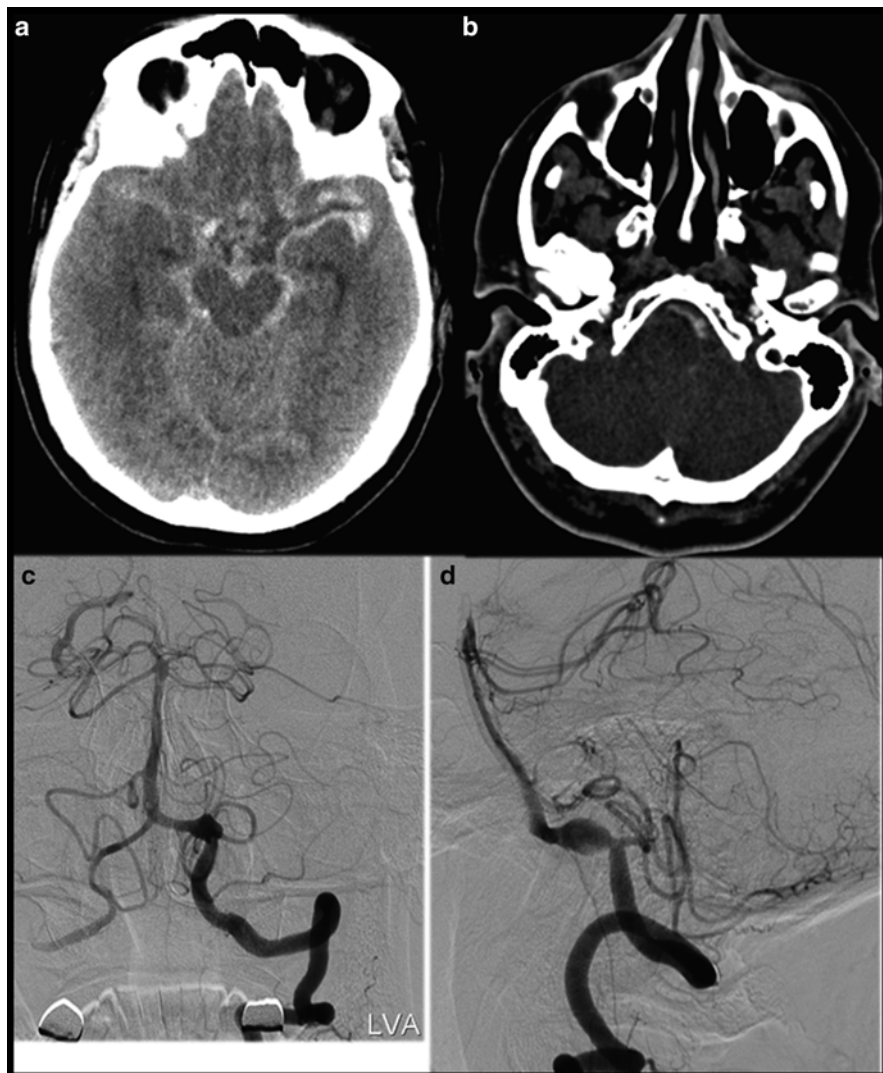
A 69 y/o old male presented with progressive headache for 4 days. NECT (a) shows massive subarachnoid hemorrhage. CTA demonstrates a dissecting aneurysm of the intracranial segment of the left vertebral artery, shown here on the source images (b). DSA confirms the presence of the dissecting aneurysm of the left vertebral artery (c and d)
